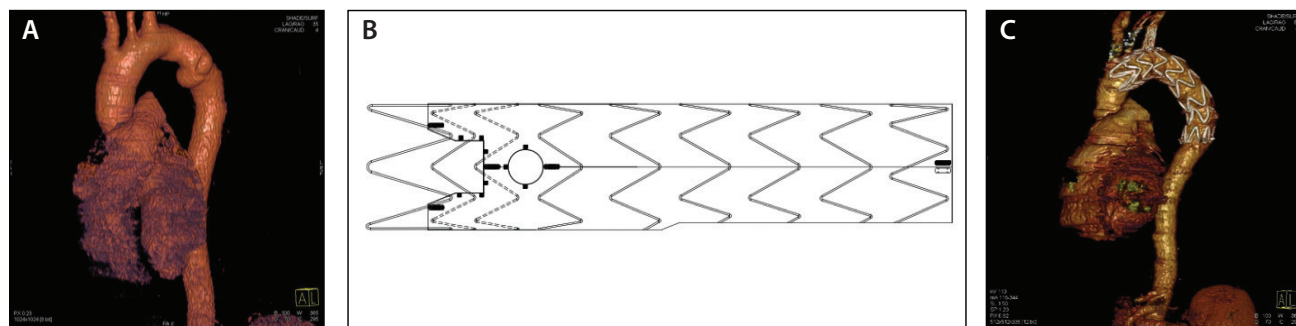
Preoperative CTA (A). Stent graft design with a scallop for the LCCA and fenestration for the LSA (B). CT at 1-month follow-up showing good seal and branch patency (C).
